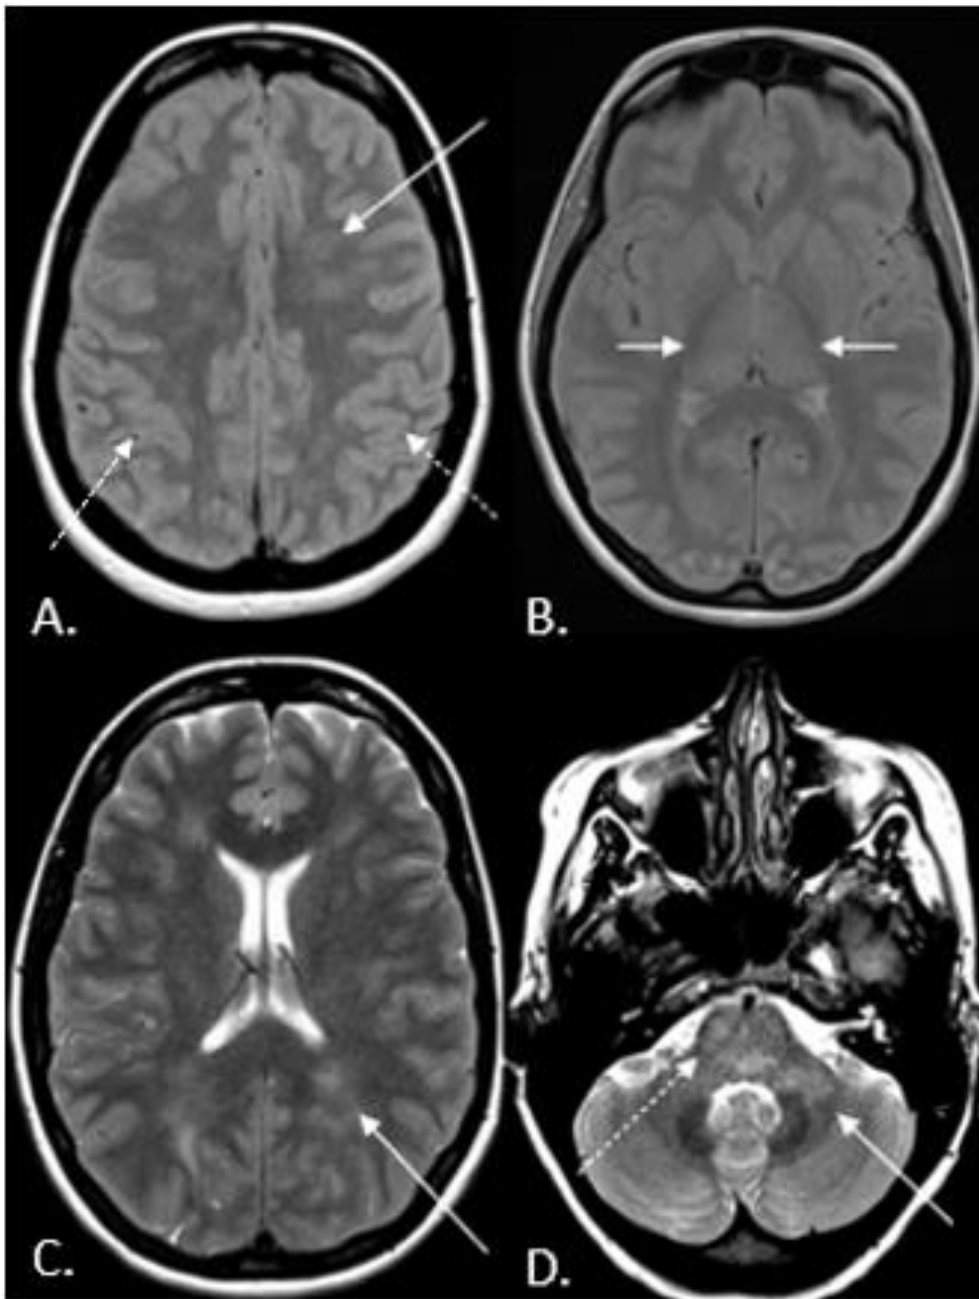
Initial MRI scan. A-B: Axial proton density (PD) images demonstrating supratentorial white matter abnormality (arrow, A) and cortical swelling (dashed arrows, A). More inferiorly, swelling of both thalami was noted (arrows, B). C-D: T2-weighted images demonstrated further hyperintensities within the supratentorial white matter (arrow, C), middle cerebellar peduncle (arrow, D) and brainstem (dashed arrow, D).
